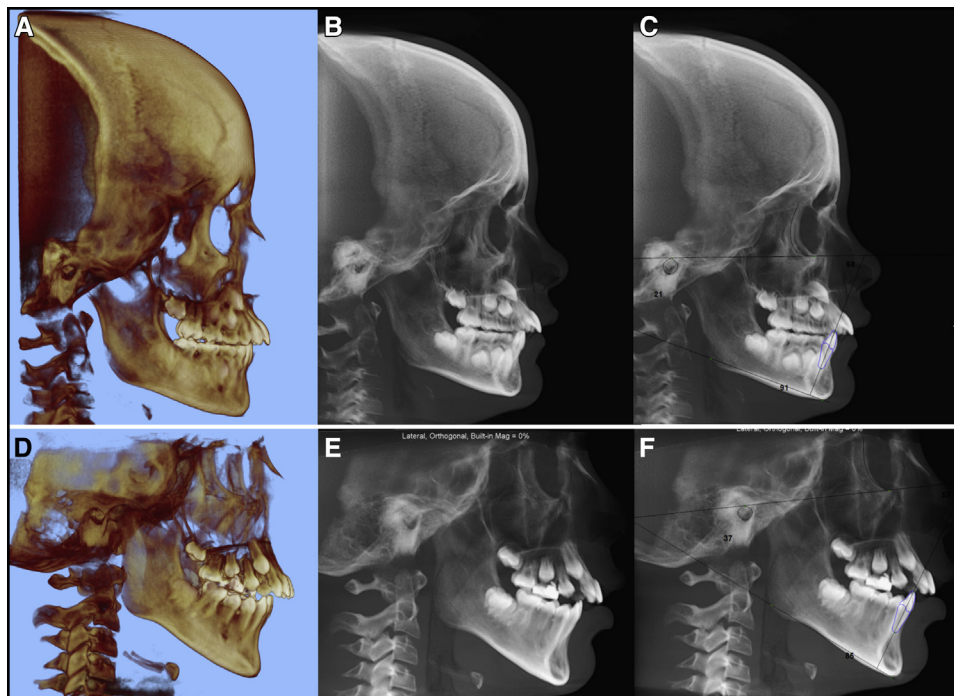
Images processed with Dolphin 3D software. *Upper row:* full size scans: A, 3D surface rendering; B, lateral cephalogram reformat obtained from the full size CBCT scan; C, digitized CBCT lateral cephalogram reformat obtained from the full size CBCT scan data. *Lower row:* limited field of view CBCT scans: D, CBCT 3D surface rendering; E, lateral cephalogram reconstructed from the limited field of view CBCT scan; F, digitized CBCT lateral cephalogram reconstructed from the limited field of view CBCT scan data.
